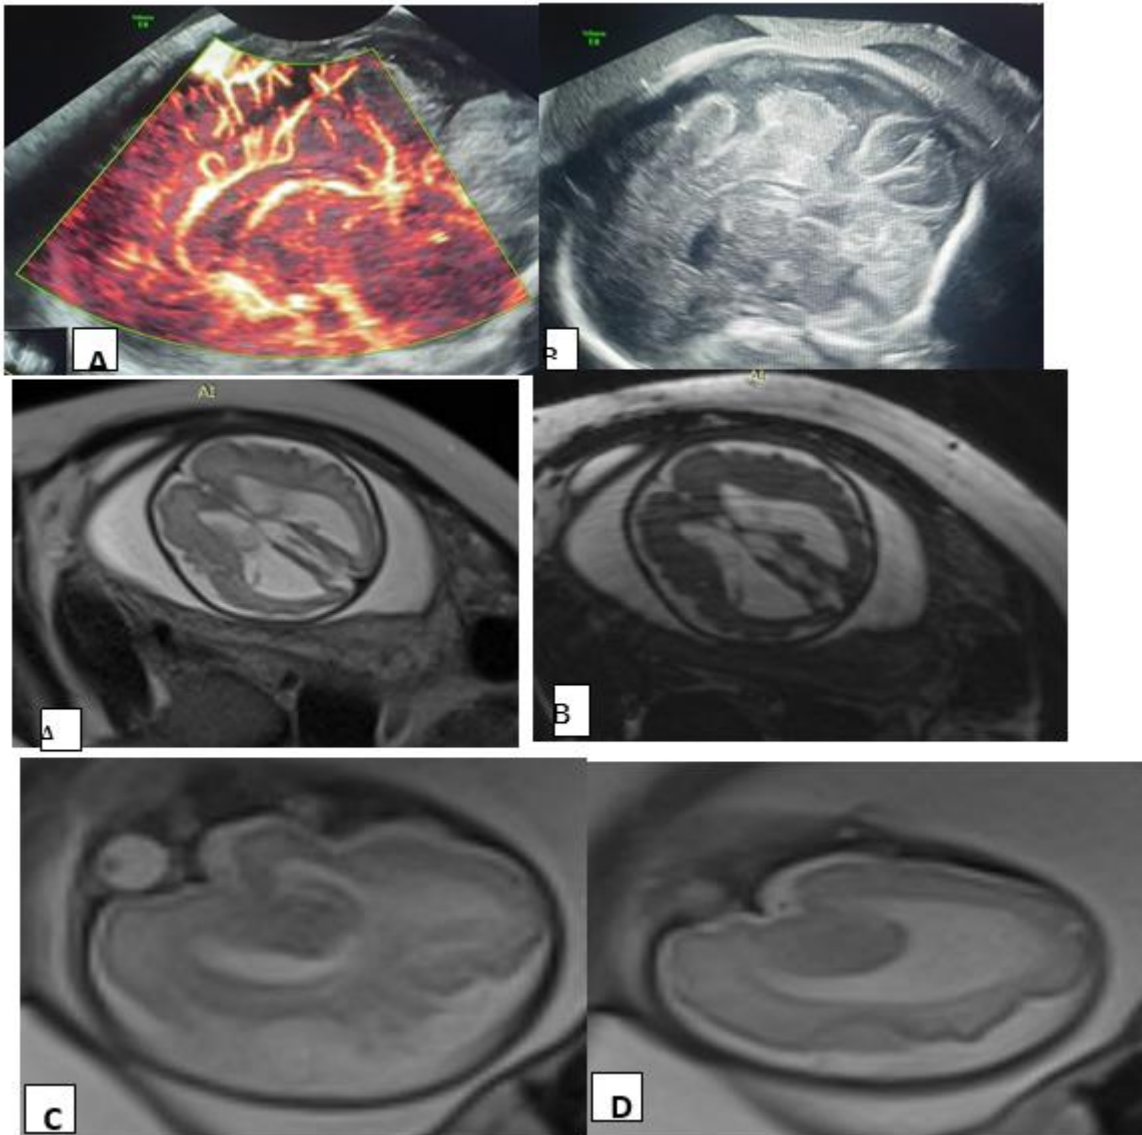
Fetus 24 ws GA with prenatal US (A and B images) referred as mild ventriculomegaly with suspected corpus callosum abnormality with abnormality of the course of pericallosal artery and referred to MRI unit for confirmation
